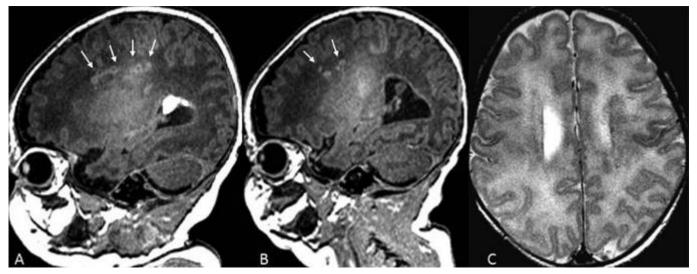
Acute white matter injury and acute periventricular leukomalacia in a term neonate. A and B. Sagittal T1 weighted images show linear and circular small focal T1 hyperintensities in the periventricular white matter (arrows). There is also evidence of some intraventricular blood. C. T2-weighted images show subtle T2 shortening in the periventricular white matter, corresponding to the areas of T1 abnormalities.
